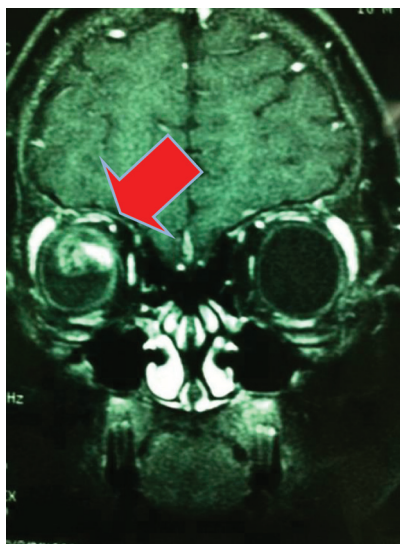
MRI brain with orbit demonstrated ill-defined mass at right posterior globe size 1.2x 1 cm in diameter.
